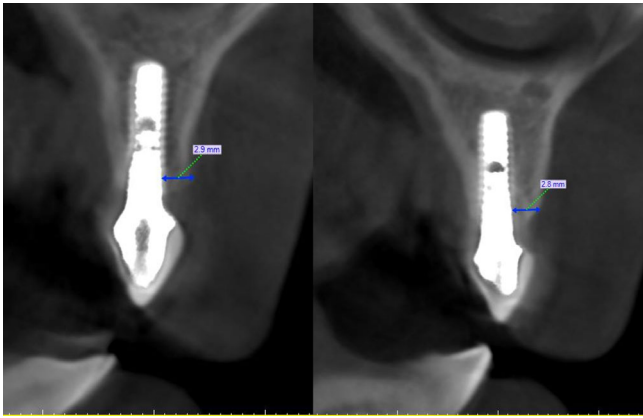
CT scan at 8 years show stability of the graft
